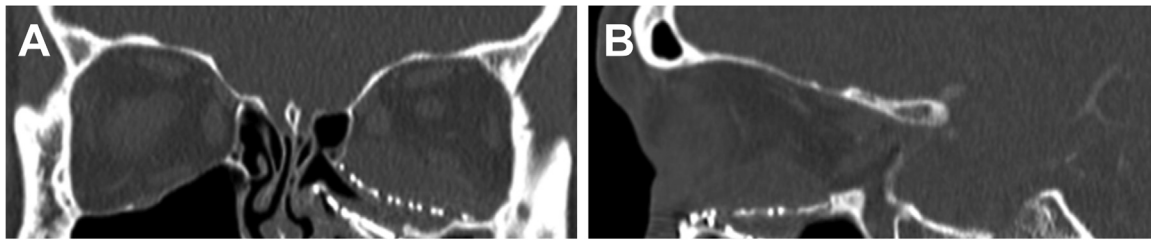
Orbital imaging at presentation: (A) coronal and (B) sagittal computed tomography scan showing a 2.8 cm ovoid subperiosteal elevation of intermediate attenuation tracking along the rostral aspect of the orbital floor implant without adjacent orbital fat stranding, consistent with a hematic cyst.
